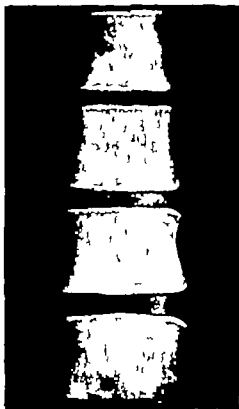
Roentgenogram of several vertebral bodies from an autopsied case of chronic myeloid leukemia showing no discernible alteration even though the marrow is everywhere diffusely infiltrated.
